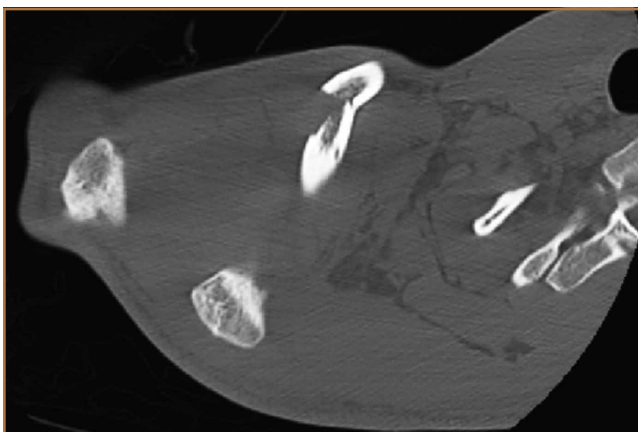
Axial cut from trauma chest computed tomography scan at acromion shows clavicle fracture and confirms posterior acromioclavicular dislocation.
